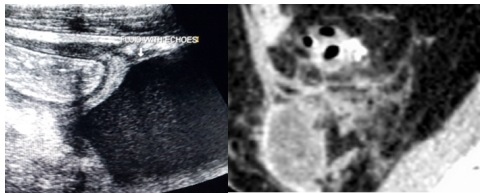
USG and CT images showing bowel wall thickening, fat stranding, presence of abscess and the presence of extra luminal free air in the collection.
